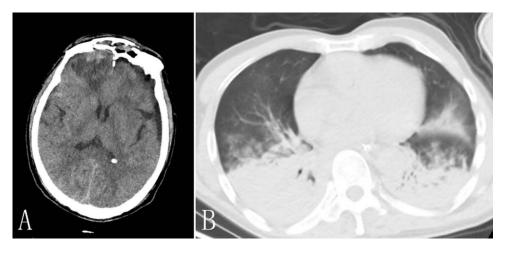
Brain and chest CT images. (A) On November 19, brain contusions were better than before, and the intracranial gas had been absorbed; (B) Increased bilateral lung exudation with consolidation on November 19.
